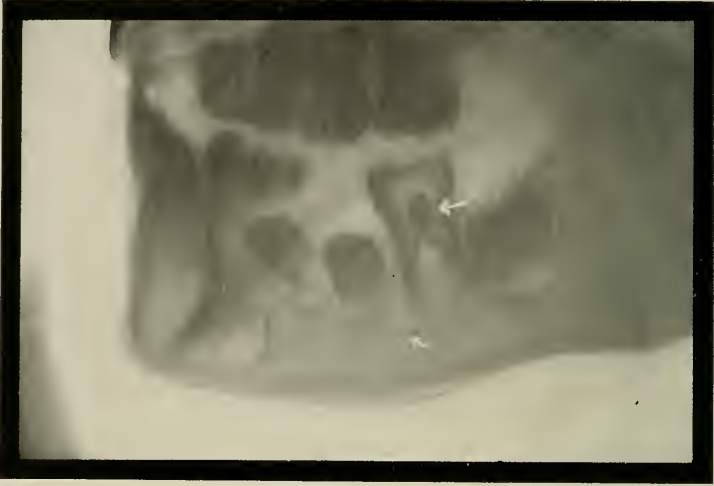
The upper arrow points to a pulp nodule in the lower first molar. (Radiograph by Pfahler of Philadelphia.)
